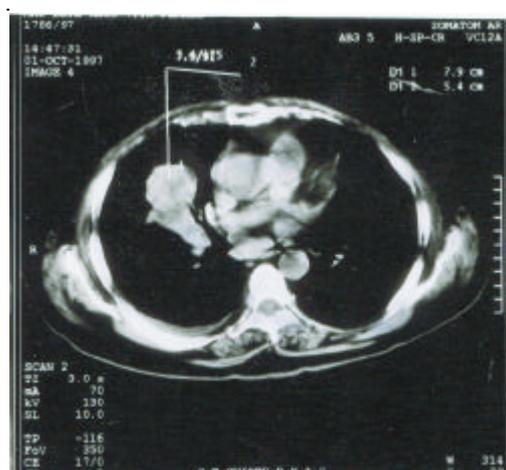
CT scan (thorax) of a 67 years old male showing right lung mass lesion, fine needle aspiration cytology (FNAC) proved it as lung cancer (Courtesy: Dr. Mohanti and Dr. Bansal)
